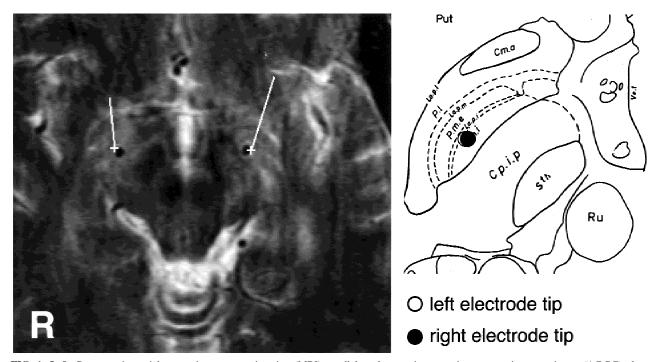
Left: Postoperative axial magnetic resonance imaging (MRI) parallel to the anterior commissure-posterior commissure (AC-PC) plane displaying the position of the electrode tips. Superimposed are the planned trajectories of the leads with a crosses indicating the target point and a line indicating direction of the lead. Right: Corresponding horizontal plate of the atlas of Schaltenbrand and Wahren (4.5 mm below the AC-PC plane). The position of left and right distal electrode pole is indicated based on stereotactic coordinates derived from intraoperative teleradiographic X-ray controls and ventriculography. Cp.i.p, capsula interna, posterior; Cm.a, commissura anterior; La.p.m, lamina pallidum mediale; La.p.i., lamina pallidum internum; P.I., pallidum laterale; P.m.e, pallidum mediale externum; P.m.i, pallidum mediale internum; Put, putamen; Ru, nucleus ruber; Sth, nucleus subthalamicus; Ve.t, ventriculus.
